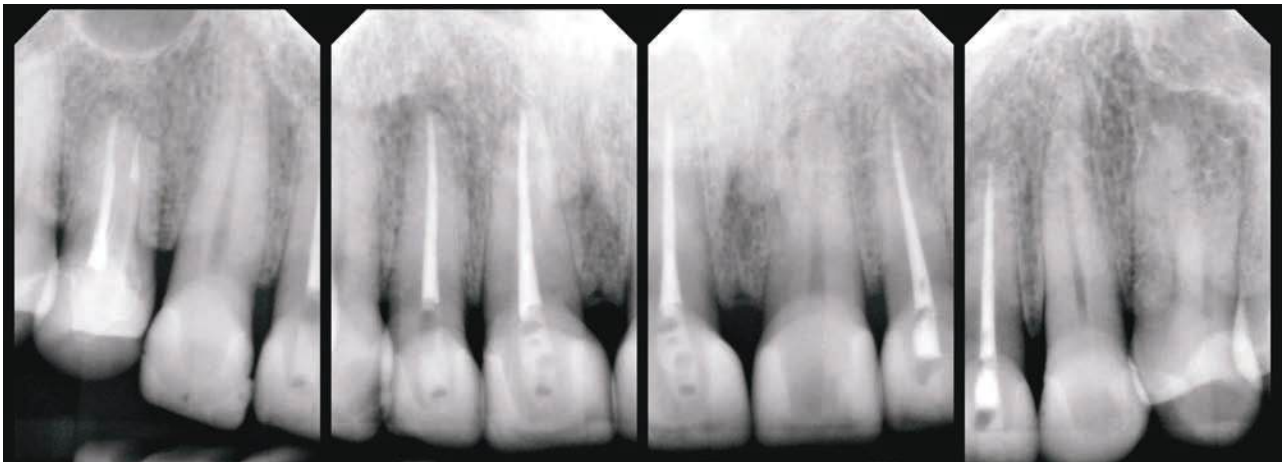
Radiographic status of the 20-year anterior rehabilitation.
